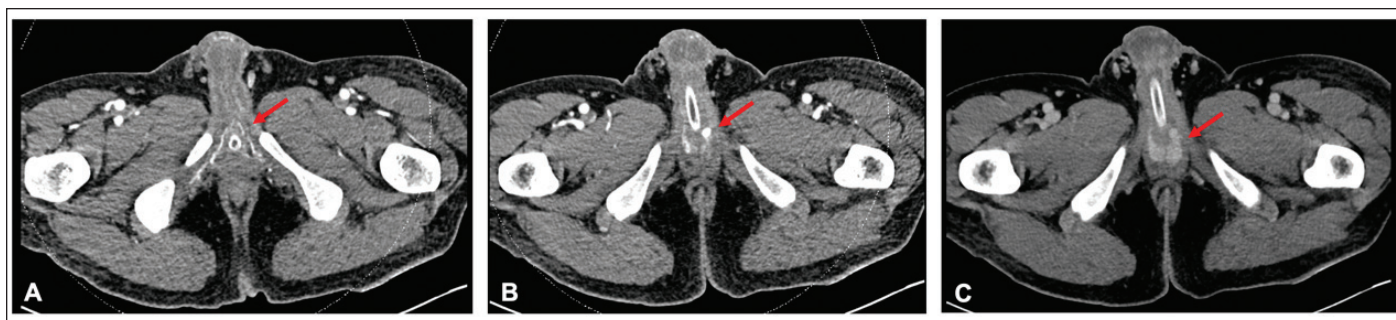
Computed tomography angiography, transverse section at the level of the pelvis. (A) Left dorsal artery on arterial phase (arrow); (B) pseudoaneurysm of left dorsal artery (arrow); (C) Contrast pooling in bulbar urethra on 10 second delayed contrast phase (arrow).
